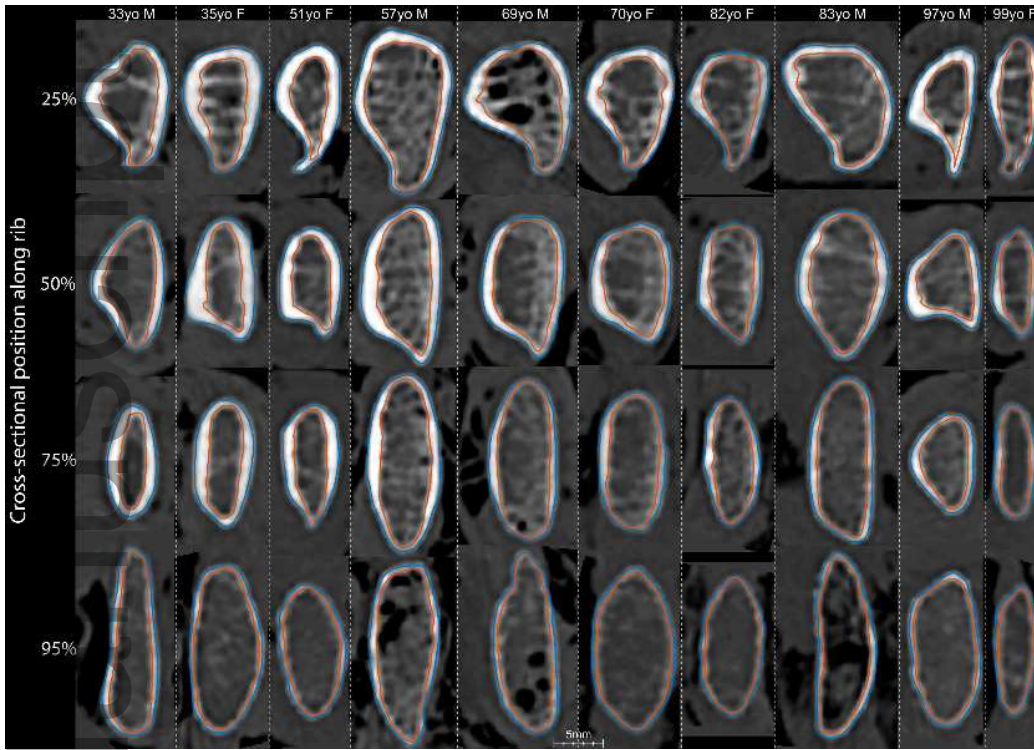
Exemplar cross-sections through CT volumes showing the predicted periosteal (outer) and endosteal (inner) cortical border using a range of male and female subjects (see upper labels) and rib locations (see left labels).
